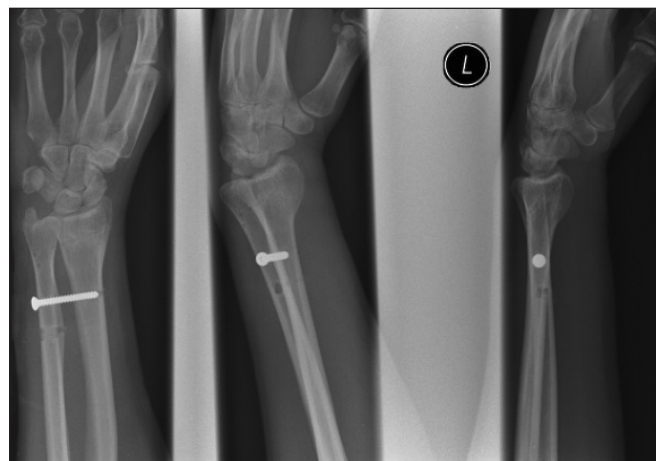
Postero-anterior, oblique and lateral radiographs with the distal radioulnar joint (DRUJ) reduced and temporary DRUJ screw in place.
